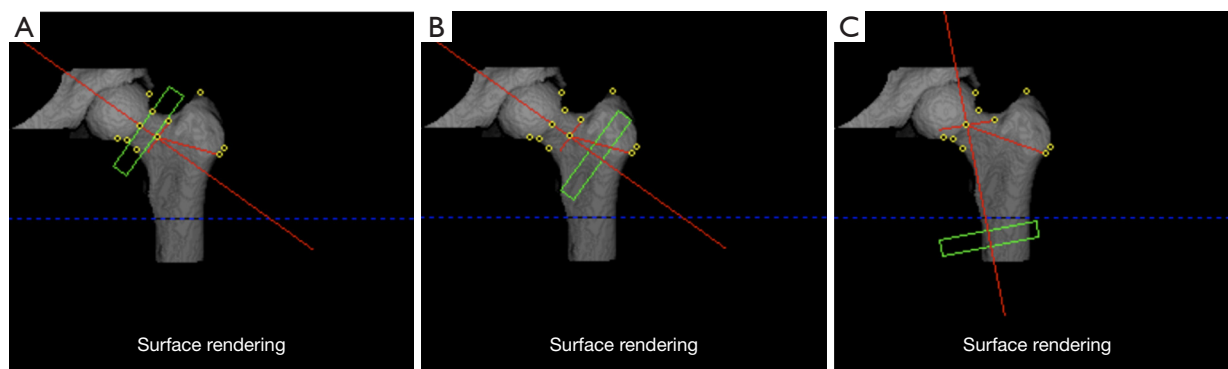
The regions measured in this study as they appeared in QCT Pro software. (A) The measured green ROI area is the FN region. (B) The measured green ROI area is the IT region. (C) The measured green ROI area is the ST region. QCT, quantitative computed tomography; ROI, region of interest; FN, femoral neck; IT, intertrochanteric; ST, subtrochanteric.
